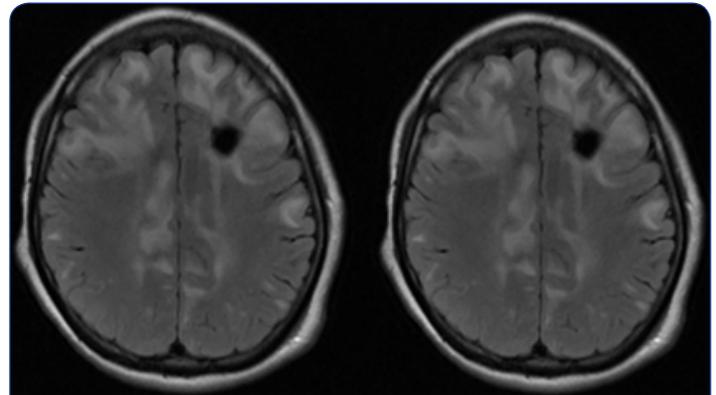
MRI classified as grade 2 (moderate vasogenic edema) because it does not compromise the entire region of a lobe.
